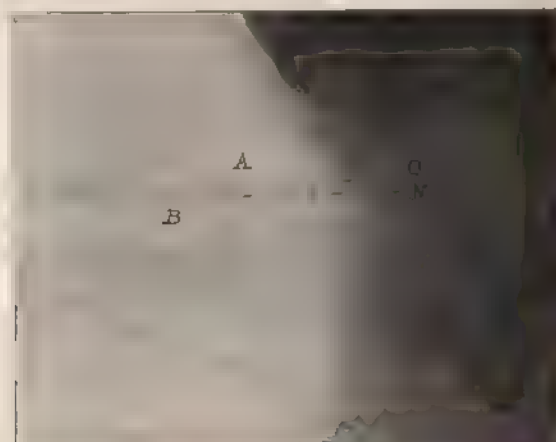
Radiograph made with tube near plane of indicators (Hansell and Sweet.)
